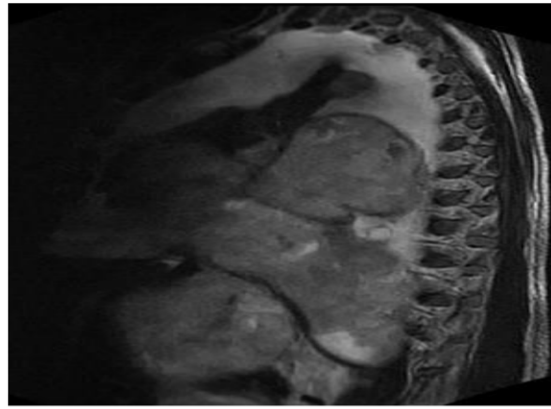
Sagittal T2 weighted MRI sequence
